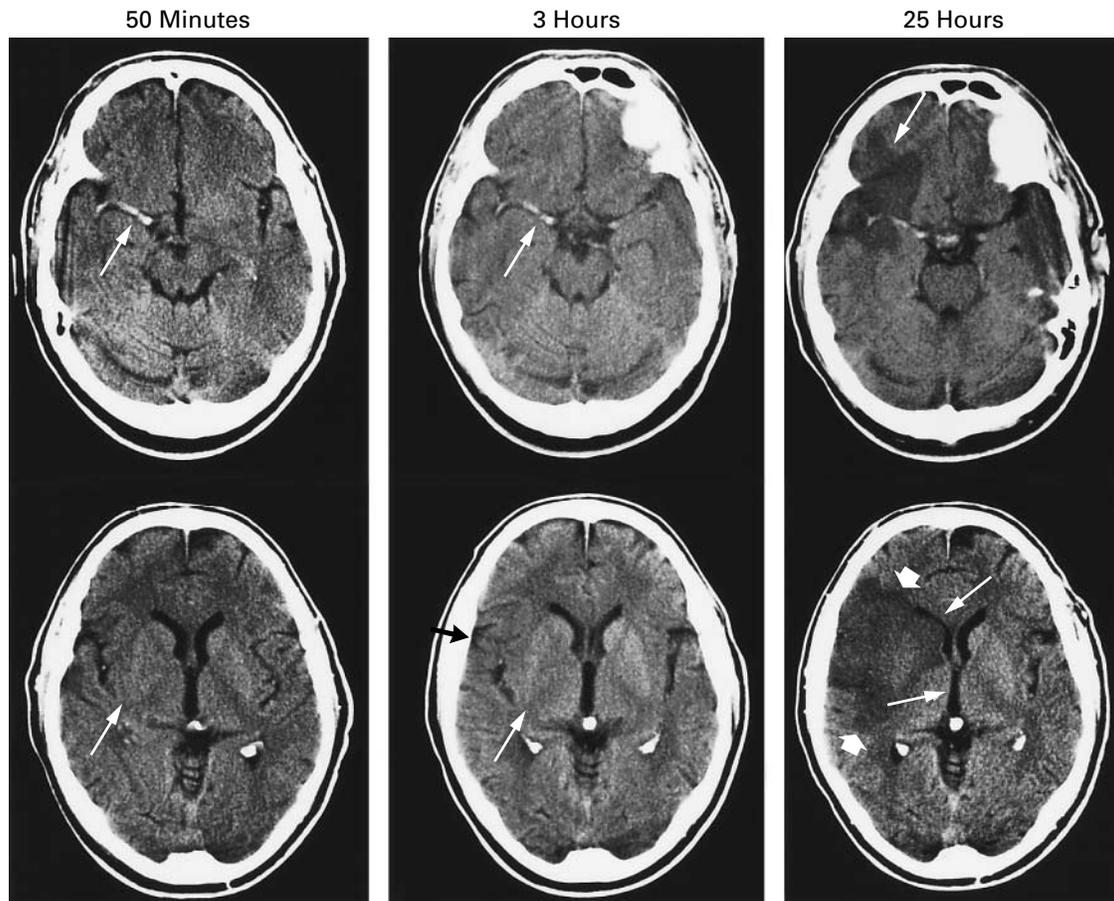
CT Scan of the Brain of a Patient with Confusion, Left Hemiparesis, and Left Hemisensory Loss 50 Minutes, 3 Hours, and 25 Hours after the Onset of Stroke.
